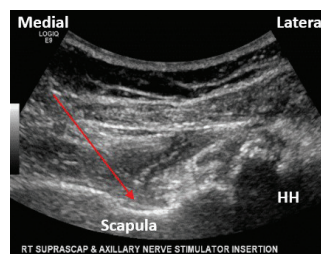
US image parallel and inferior to the spine of the scapula. The red arrow shows the medial-to-lateral approach to the SSN at the spinoglenoid notch. US: ultrasound; SSN: suprascapular nerve; HH: humeral head.
